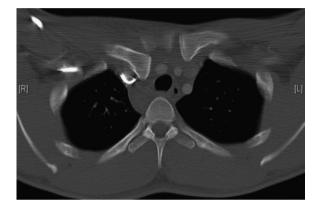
CT angiogram reveals the close proximity of the medial end of the clavicle to the right brachiocephalic vein.
